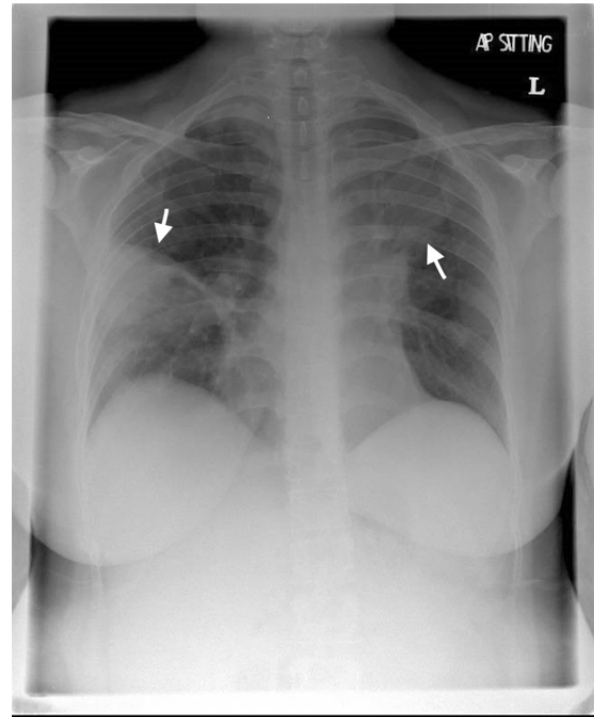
Chest X-ray showed mild reduction in size of the right middle zone consolidation with gas lucencies over the opacity suggestive of cavitation (downward arrow), along with left upper lobe collapse (upward arrow).
